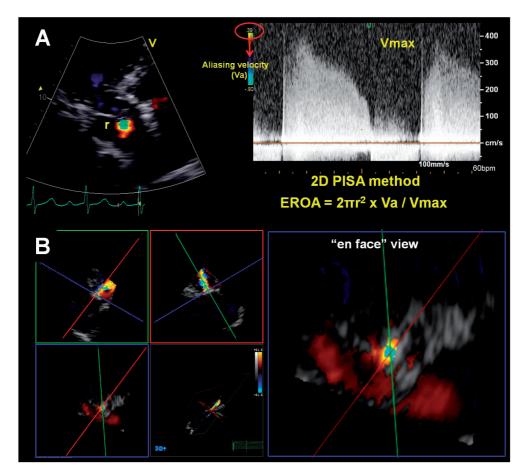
Quantitative assessment of aortic regurgitation severity using the proximal isovelocity surface area (PISA) method using conventional 2-dimensional Doppler echocardiography (panel A). Real-time 3-dmensional (3D) echocardiography permits unlimited plane orientation, allowing for the true cross-sectional area of the regurgitant jet to be planimetered, without multiple computation steps (panel B).
